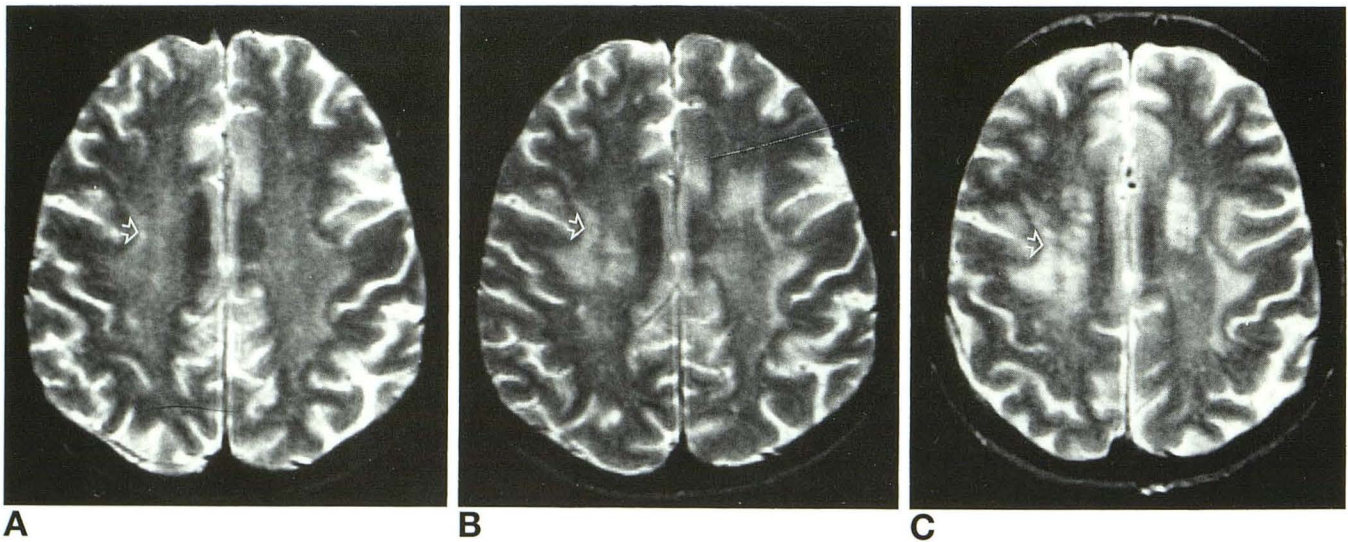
Patient 3, centripetal progression. Axial T2-weighted acquisitions (2000/80) at the level of the centrum semiovale.
